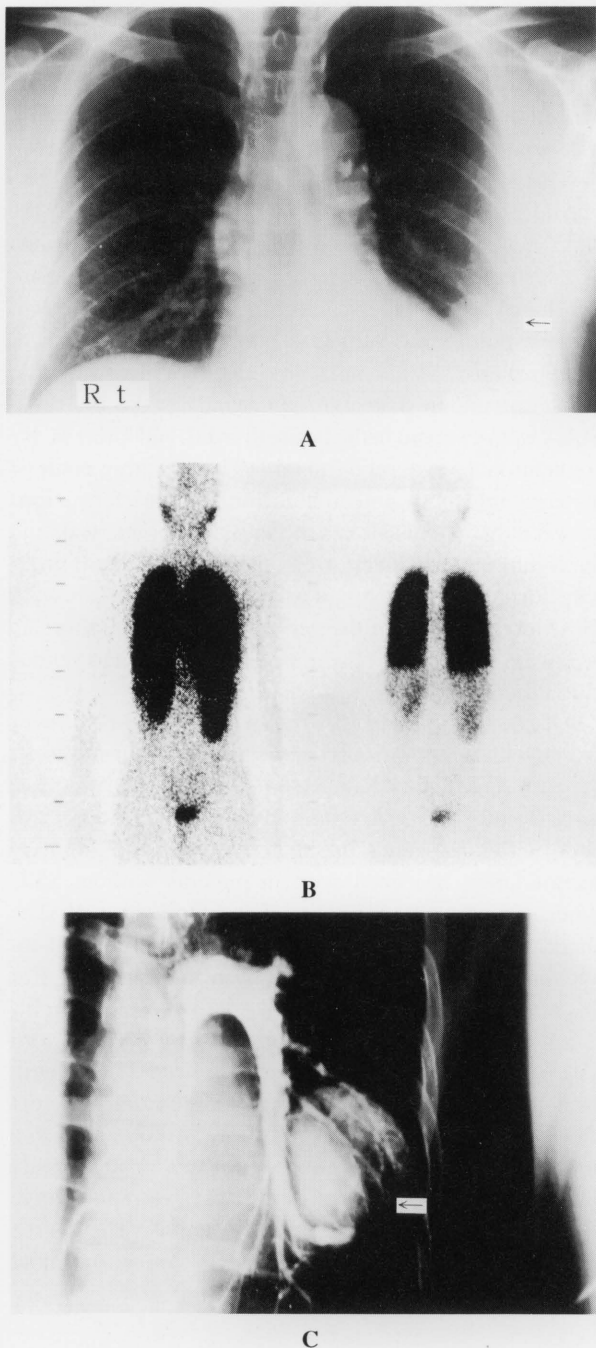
A. Posteroanterior chest X-ray showing a well defined oval lesion in the left lower lung field (→). B. ^{99m}Tc -MAA lung perfusion scan showing an abnormal uptake in the parotid glands, thyroid, spleen and kidneys. C. Selective left pulmonary angiogram demonstrated a single pulmonary arteriovenous fistula (→).
